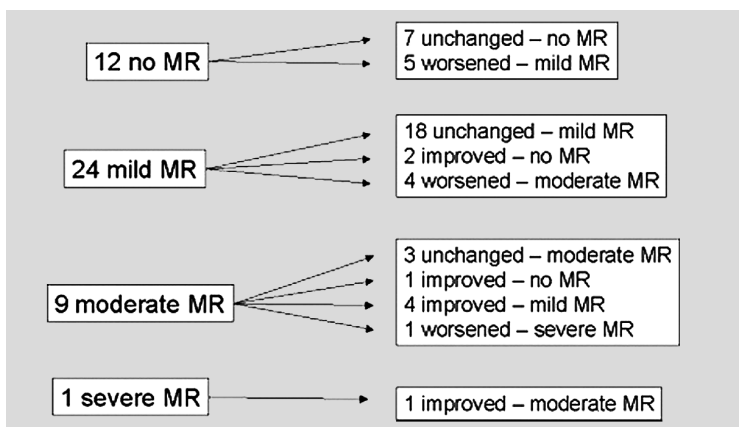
Changes in MR before and after treatment in patients with available pre and postdischarge echocardiography ($n=46$).
